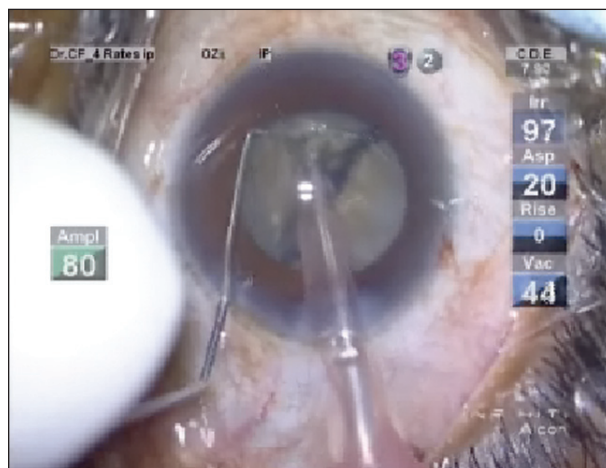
The author initiates nuclear disassembly in the capsular bag using OZil Torsional ultrasound and a Fonseca chopper.
